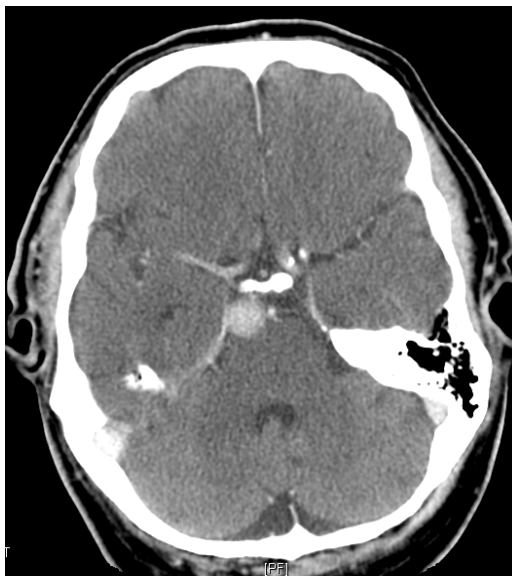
Contrast enhanced CT image of clival meningioma in a 69-year-old man. Dural tail is visible.
